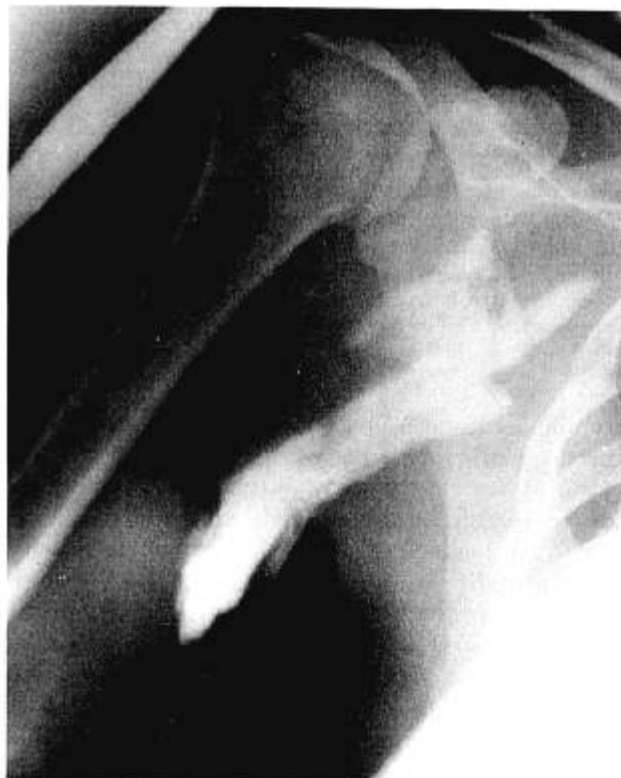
Roentgenogram demonstrating the placement of the catheter within the axillary sheath following the injection of 10 ml Renografin 60®.
